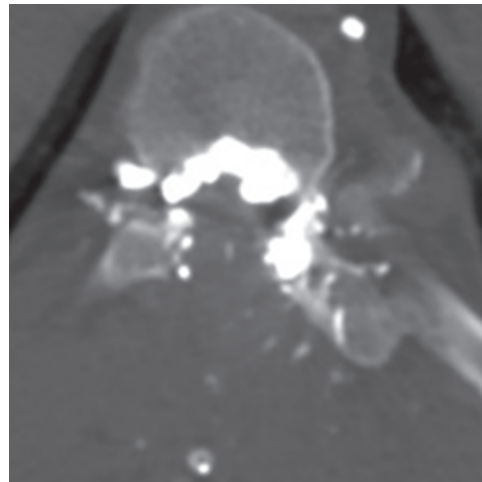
CT scan dorsal spine axial section image showing laminectomy and residual glue in the canal
